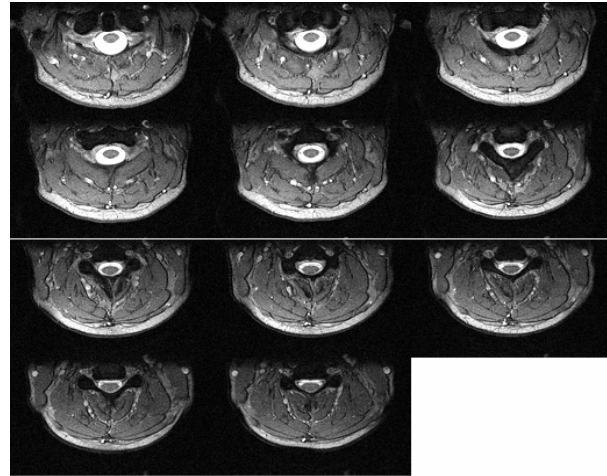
MRI series of patient 1
